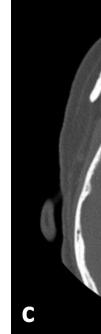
Preoperative axial HRCT images showing polypoid lesions in both nasal cavities as well as bilateral frontal, maxillary, and ethmoid sinusitis. The sphenoid sinuses are spared.
